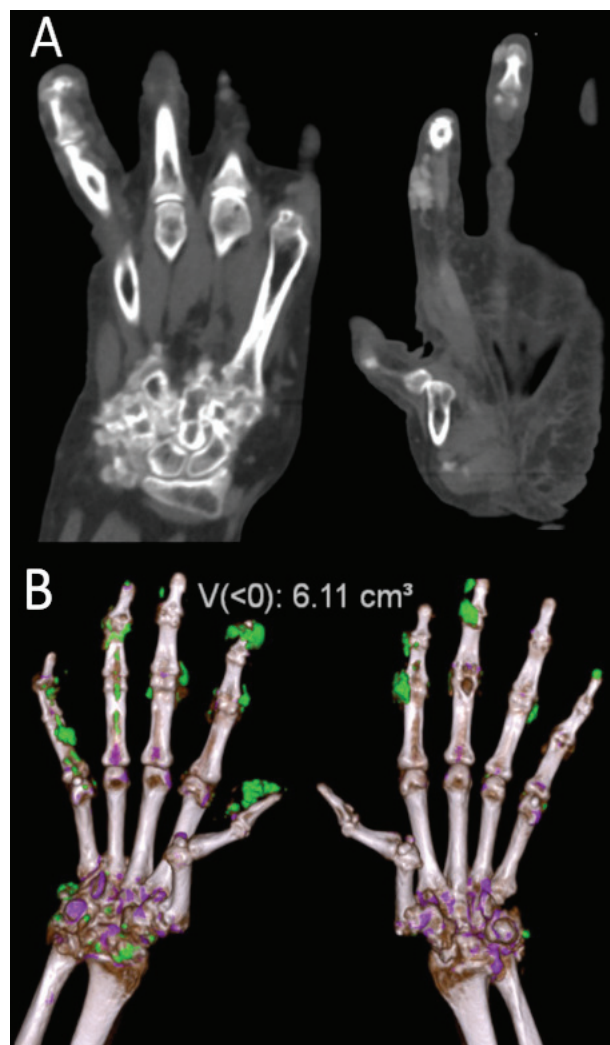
Dual-energy CT. A: coronal multiplanar reformatted grayscale images of hands/wrists showing bone erosions at left wrist and fingers of both hands, with high-attenuating material adjacent to the erosions and along the metacarpophalangeal and proximal and distal interphalangeal joints, indicative of monosodium urate deposits. B: corresponding volume-rendered color-coded dual-energy image of wrists/hands showing numerous urate deposits (depicted in green) along the metacarpophalangeal and proximal and distal interphalangeal joints and in the both wrists. Bilateral dislocation of first metacarpophalangeal joints can also be observed. Automated quantification of urate volume is displayed at the top of the image.
